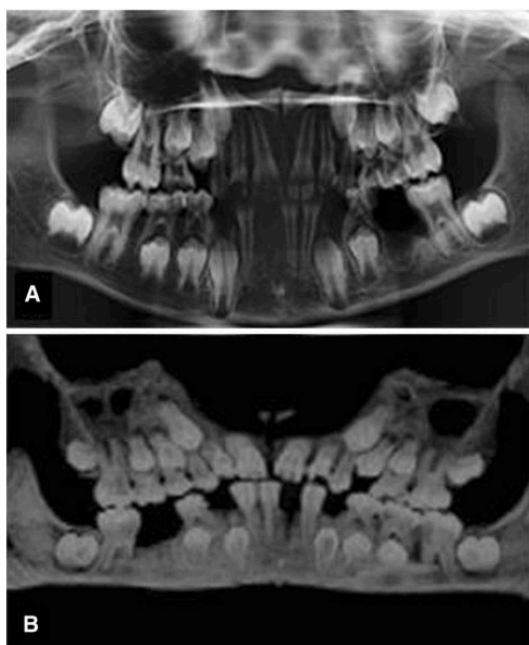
a Radiographic images traditionally used for comparison in Schour and Massler method [52]. b MDCT images created using OsiriX software package. It is evident from these images that a comparable level of detail is achieved using MDCT to carry out this technique successfully
